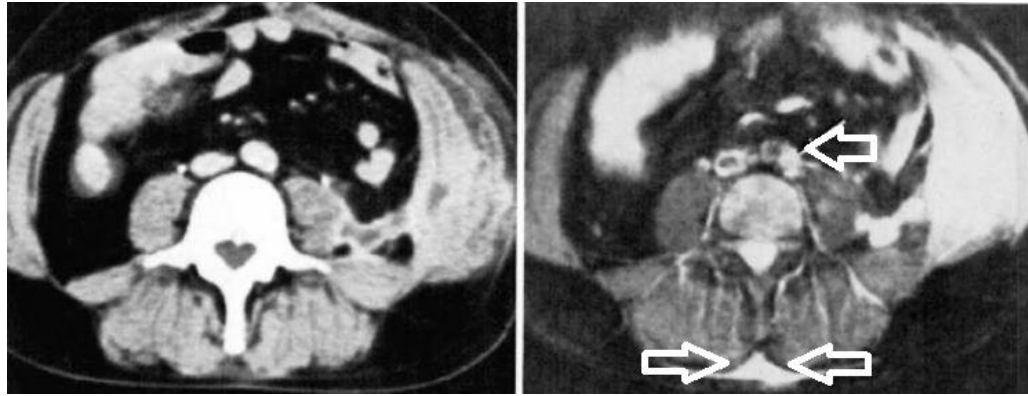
Psoas abscess. CT (left) and STIR (right) images of the abdomen, 1985. Areas of abnormality (lymph node and fluid) are highlighted on the STIR image (arrows) but are not seen on the CT image.
